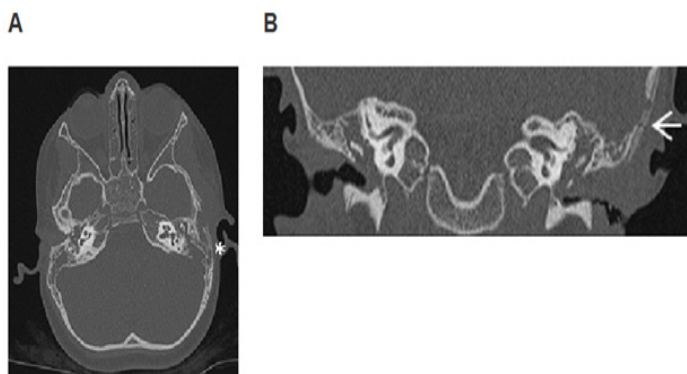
Computed tomography (CT) scans of the petrous bone. A. Coronal computer tomography. Occupation of the tympanic and mastoid cavities, bone erosion, insufflation, and periosteal reaction in the left temporal bone is indicated by a white arrow. B. Transverse computer tomography image showing a left side occupation of the tympanic and mastoid cavities (white asterisk). Bone extensive cortical bony destruction involving left petrous, squamous, and mastoid bone.
